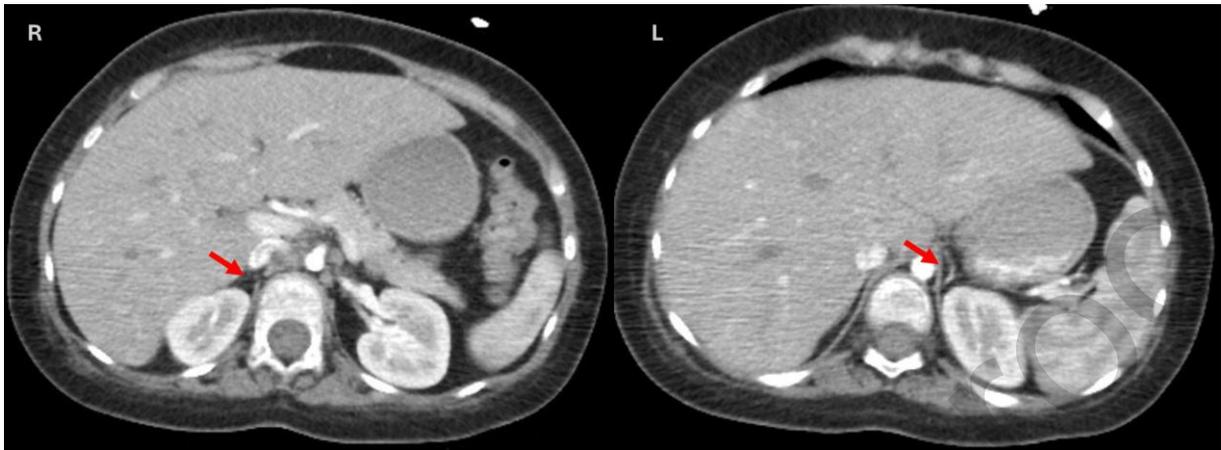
CT imaging of the patient's adrenal gland
